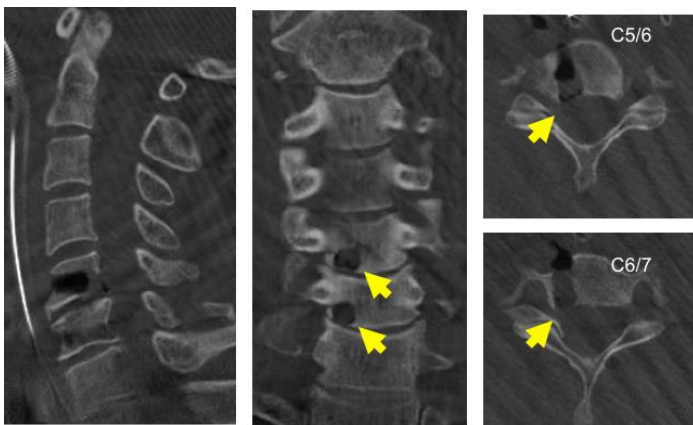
Intraoperative CBCT images by Artis zeego during transvertebral anterior foraminotomy
